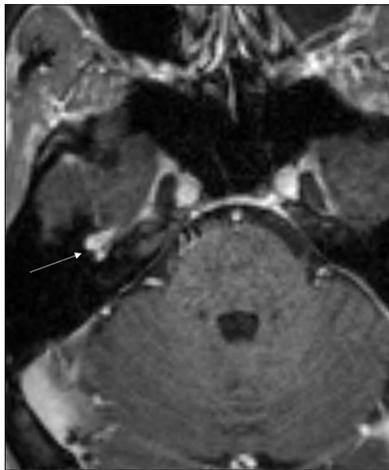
Axial T1 fat-saturated enhanced magnetic resonance imaging demonstrating an enhancing lesion along the right facial nerve geniculate ganglion within the right petrous bone.
